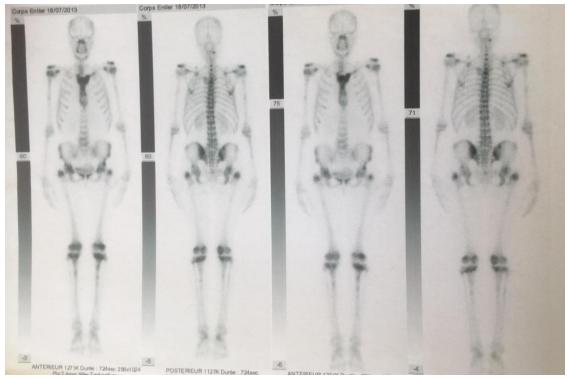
Bone scintigraphy revealing several foci of hyperfixation in the sternum, humerus, femurs and pelvis.
